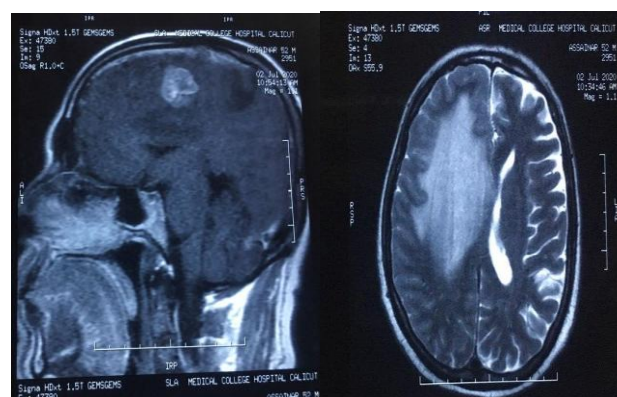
(a, b): MRI showing lesion in right parasagittal area with mass effect
